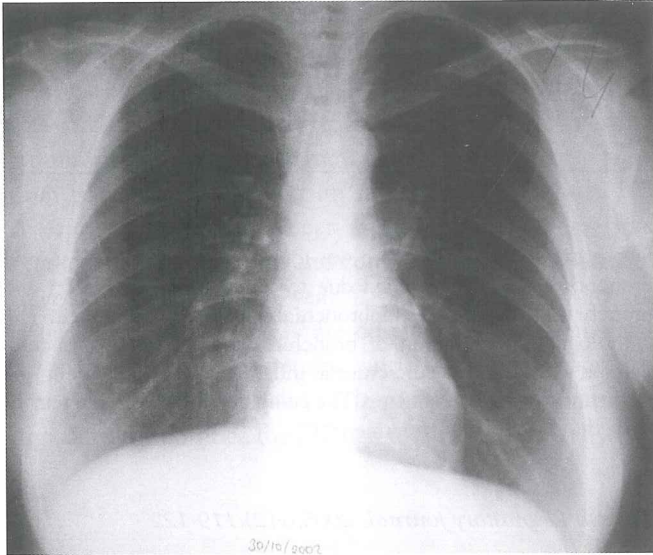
The chest X-ray of the patient on admission.
